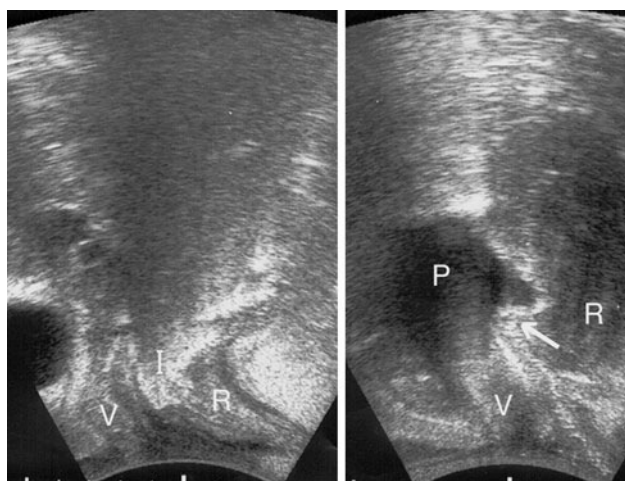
Transperineal ultrasound: *Left side*, at rest, no pessary. *Right side*, patient straining. Pessary “P” in the apical part of the vagina. Note “stretching out” of the intussusception (white arrow) I intussusception, V vagina, R rectum
